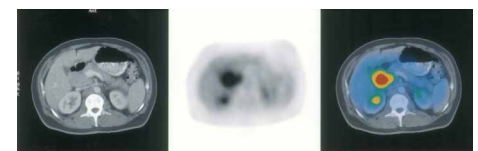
Fusion of the abdomen CT and PET transaxial imaging shows abnormal hypermetabolic activity involving a paraduodenal mass.
